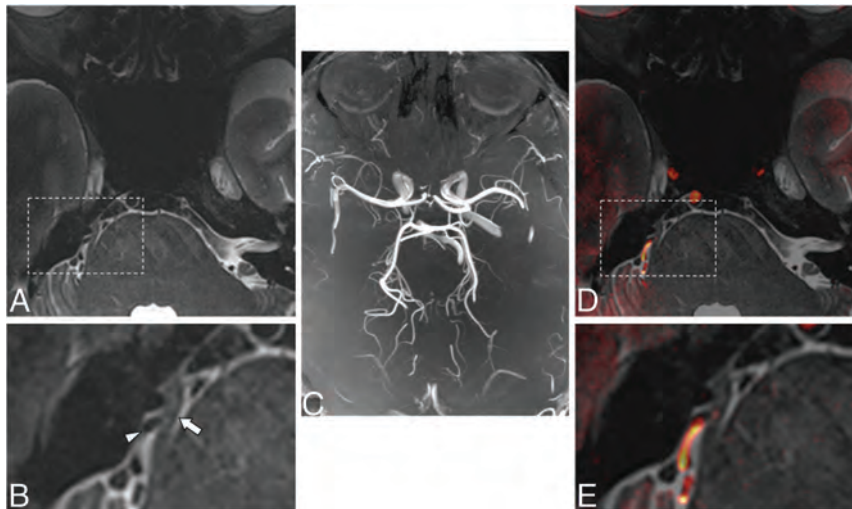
Axial T2-weighted image at 7T of a patient with classic trigeminal neuralgia and associated right-sided neurovascular compression (arrow indicates right trigeminal nerve; arrowhead indicates artery in A and magnified inset B). There may be subtle hyperintensity within the nerve itself. Whole-brain maximum intensity time-of-flight projection at 7T (C) and fused gray-scale T2 and color-encoded TOF (D and E, at same locations as A and B) show orientation of the vessels and nerve and resultant neurovascular compression.
